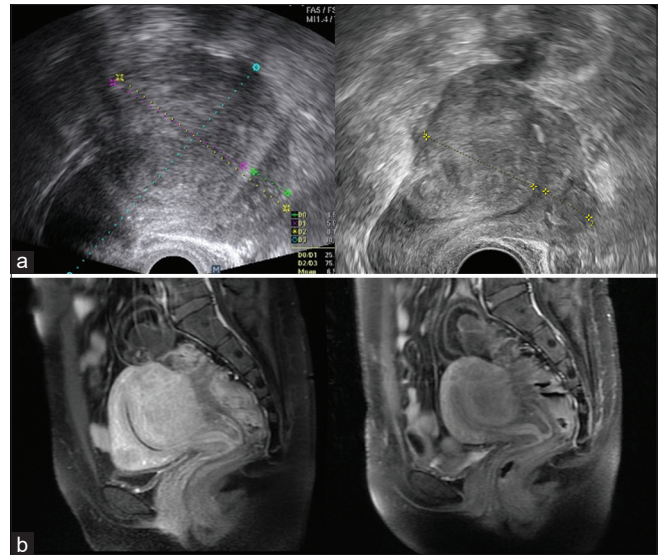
Endometriosis image finding of the patient. (a) Transvaginal sonography of the uterus before (right) and after (left) HIFU showed asymmetrical uterine wall and thickening of posterior uterine wall, indicating focal adenomyosis. The posterior wall thickness was 5.9 cm (right) and 4.1 cm (left). (b) T1-weighted MRI with contrast of uterus before (right) and after (left) HIFU showed thickening of the junctional zone and an ill-defined mass over the posterior uterus with multiple hemorrhagic foci in it, which was compatible with focal adenomyosis. The mass size was about 6.8 cm × 5.6 cm × 7.1 cm (right) and 5.8 cm × 4.3 cm × 6.6 cm (left). HIFU: High-intensity focused ultrasound, MRI: Magnetic resonance imaging
